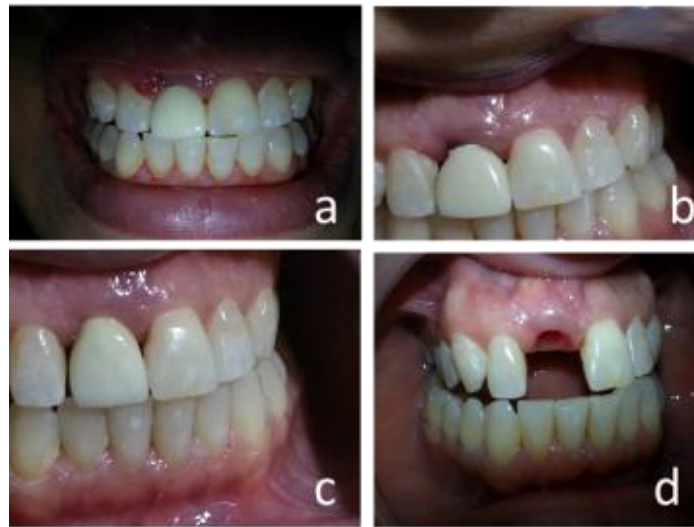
Postoperative clinical views with different smile line and radiographic views
